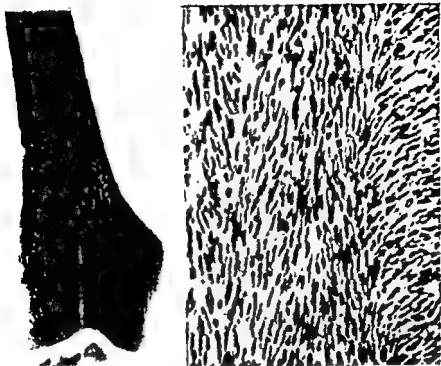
Periosteal fibrosarcoma. *Left*, the roentgenogram shows a faint periosteal tumor and erosion of the cortical and cancellous bone. *Right*, characteristic herringbone pattern of nuclei. (From Geschickter and Copeland, *Tumors of Bone*, J. P. Lippincott Co.)
